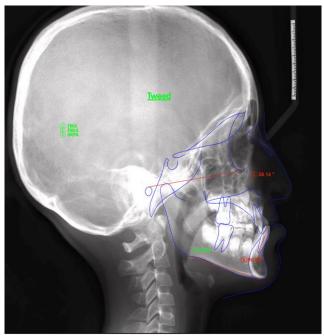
AI-based FMA measurement using WebCeph Software [Description: Figure showing the AI-based identification of anatomical landmarks (porion, orbitale, gonion, menton) and calculation of the FMA angle on a digital cephalometric radiograph using WebCeph software.]
